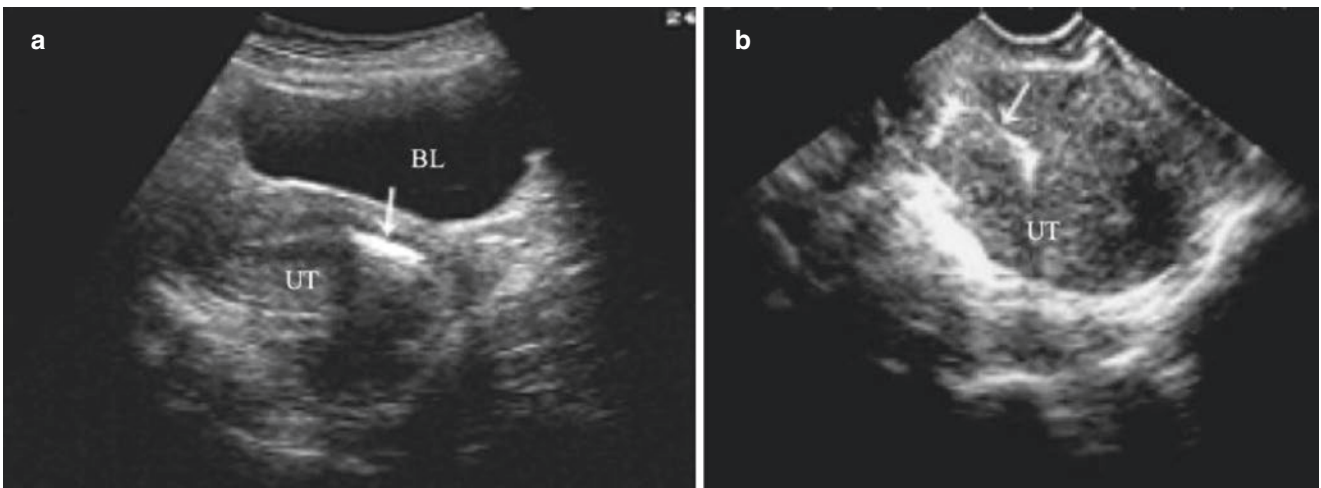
IUD move down to the internal cervical os. (a) Transabdominal ultrasound shows that the bottom of IUD reach to the internal os of the cervix. (b) Transvaginal ultrasound shows that the bottom of IUD reach to the internal os of the cervix
